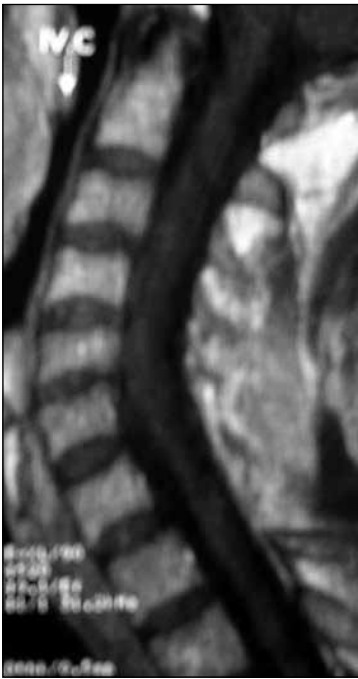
At 6 months post-operative, control MRI revealed there was no evidence of tumor's recurrence.
